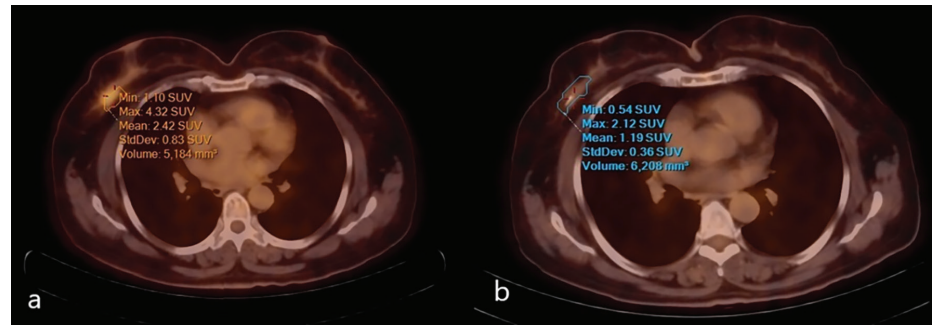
Changes in fluorine-18 fluorodeoxyglucose positron emission tomography/computed tomography parameters at (a) baseline and (b) after neoadjuvant treatment of the same patient. This patient, whose ΔSUV_{max}, ΔSUV_{mean} changes were evident, had a pathologic complete response according to pathology. SUV, standardized uptake value.
